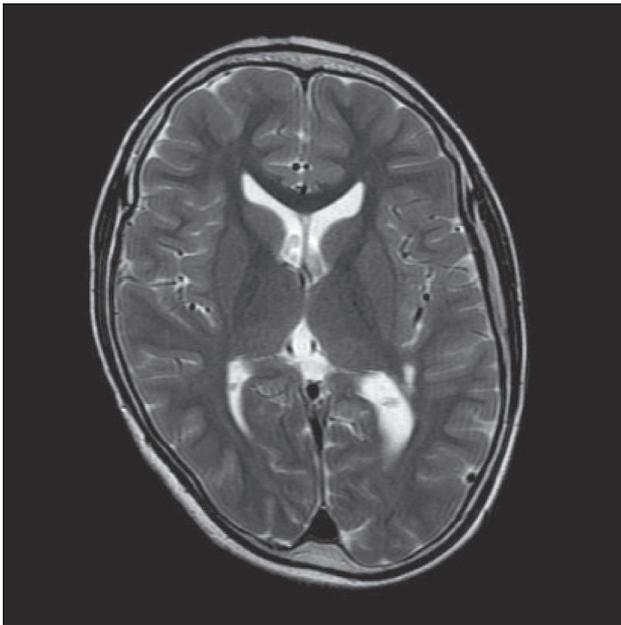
Brain MRI of Case 3. Initial brain MRI was normal. At five years of age, however, MRI T2-weighted images revealed high-intensity signal lesions in left posterior periventricular white matter.
